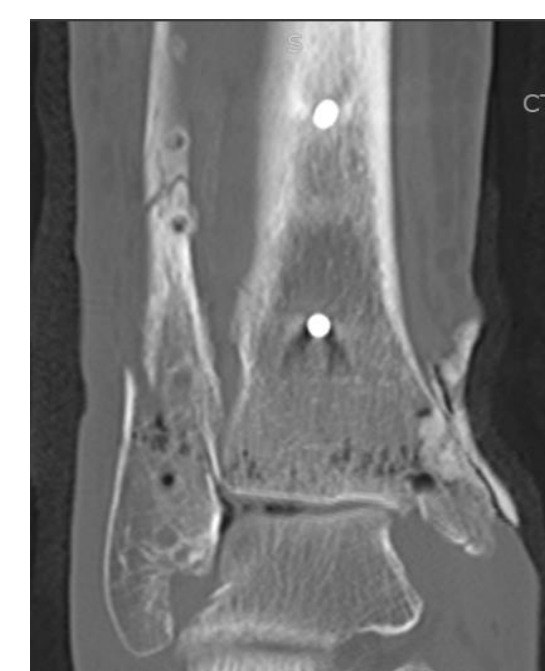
AP(A) and lateral(B) CT views post initial hardware removal
